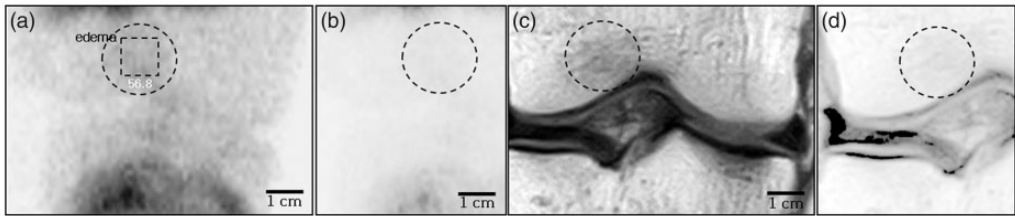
Edema has no injurious effect on trabeculae. Smallest edema in the current series occurred in the right femoral intercondylar fossa in a 16-year-old male student following a motor vehicle accident (circle). a Naïve ^{99m}Tc-HDP pinhole bone scan shows smallest 2-cm edema. Tracer uptake in unit area measured by ImageJ densitometry was 56.8 AU, close to the lowest value for edema. b Gamma correction view shows complete suppression of tracer uptake (circle). c Corroborative coronal T1-weighted (460/26) magnetic resonance (MR) image shows presence of edema with dark signal intensity (circle). d Gamma correction MR image shows suppression of dark signal MR intensity of edema (circle)
